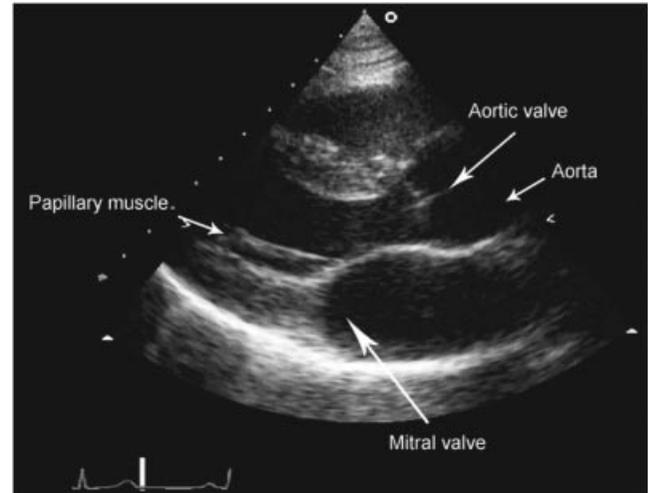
Parasternal long-axis TTE demonstrating the left ventricular cavity and mitral and aortic valves.
